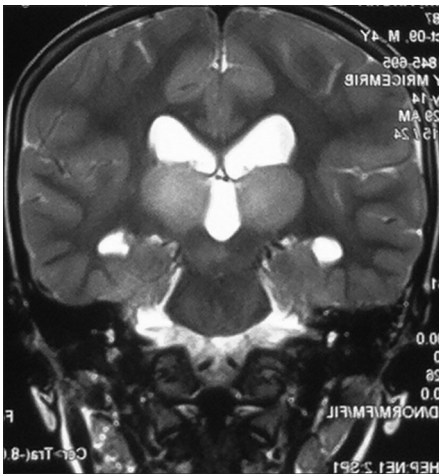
MRI T2 weighted image showing areas of hyper intensity involving caudate nucleus and thalamus
